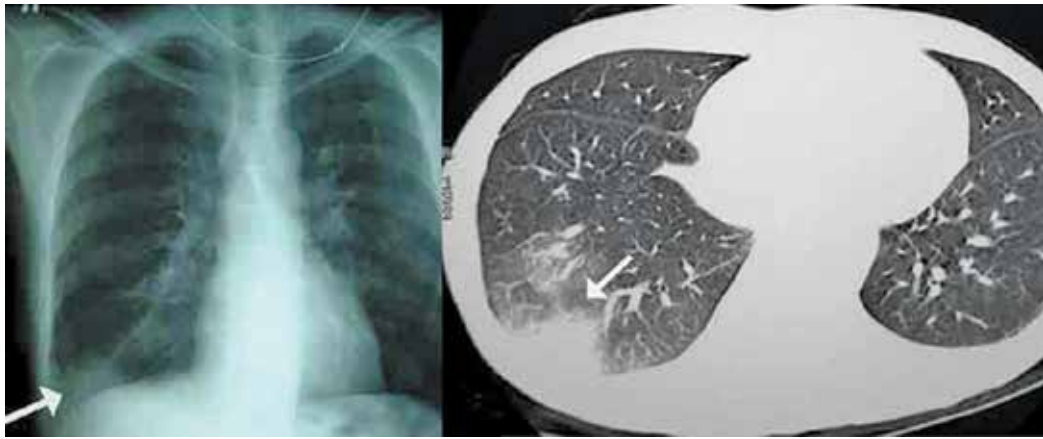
Chest X-ray and CT showing a peripheral pulmonary infarct (arrow)
